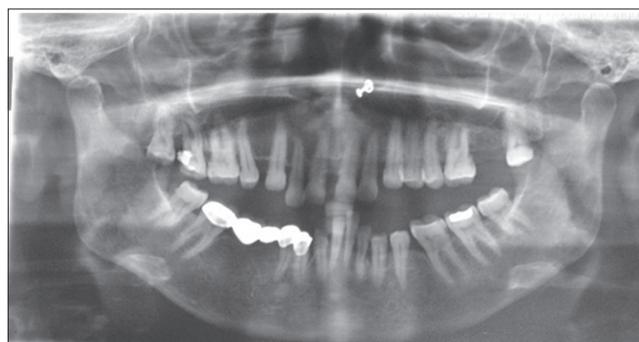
orthopantomography showing no abnormalities
